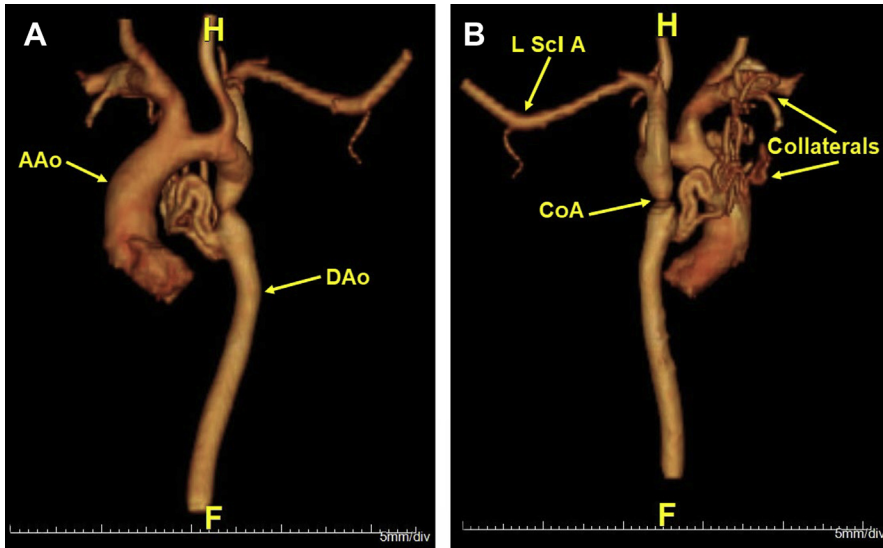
Volume-rendered 3D reconstruction from a computed tomography of the aorta (*A*, anterior view; *B*, posterior view) in a 43-year-old man who presented to the emergency department with long-standing, poorly controlled hypertension. The study obtained demonstrates severe, native coarctation of the aorta in the presence of marked collateral formation. AAo, ascending aorta; DAo, descending aorta; L Scl A, left subclavian artery.
